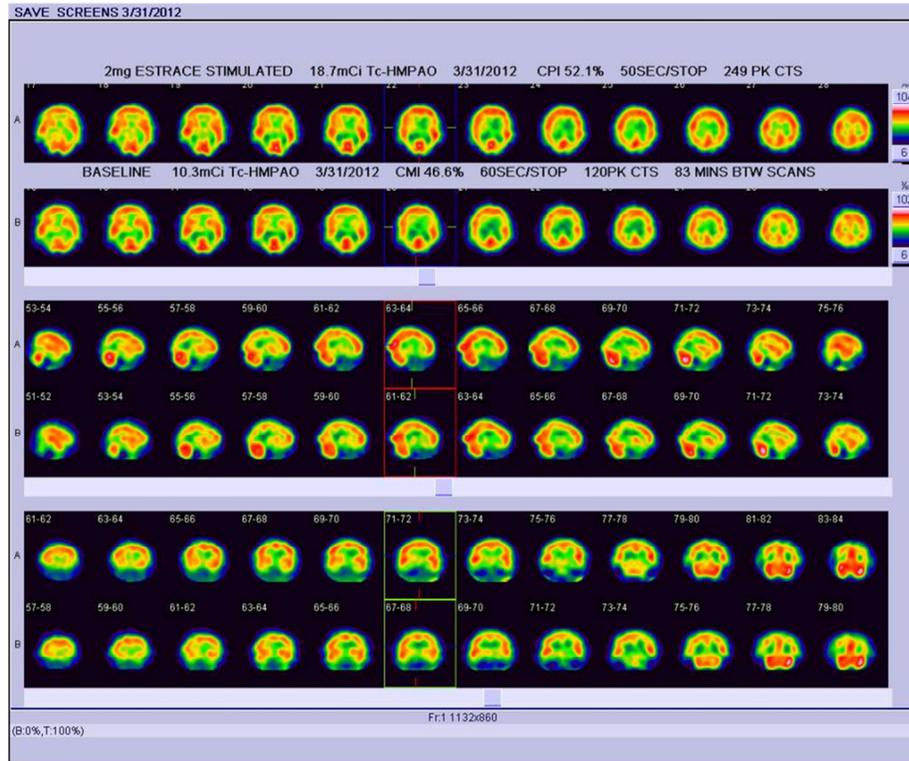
Brain SPECT for a year-old man with a clinical diagnosis of Alzheimer's disease (TYM score 22) whose brain SPECT below suggests cerebrovascular disease affecting the right parieto-occipital area and more advanced neurodegeneration affecting the left parieto-occipital area, quite possibly amounting to mixed dementia. Such a pattern is typical (affects over 70%) of patients presenting with memory loss.
